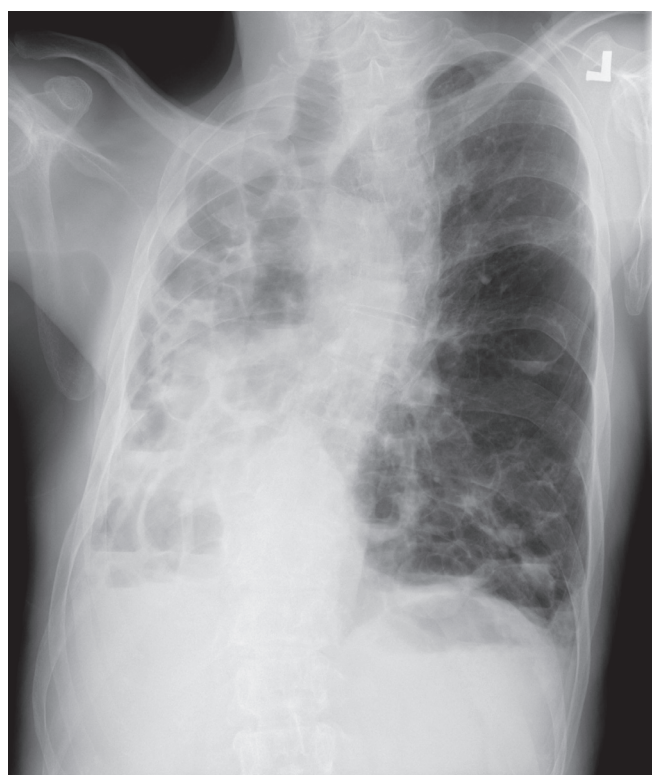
Chest X-ray for Mr T
